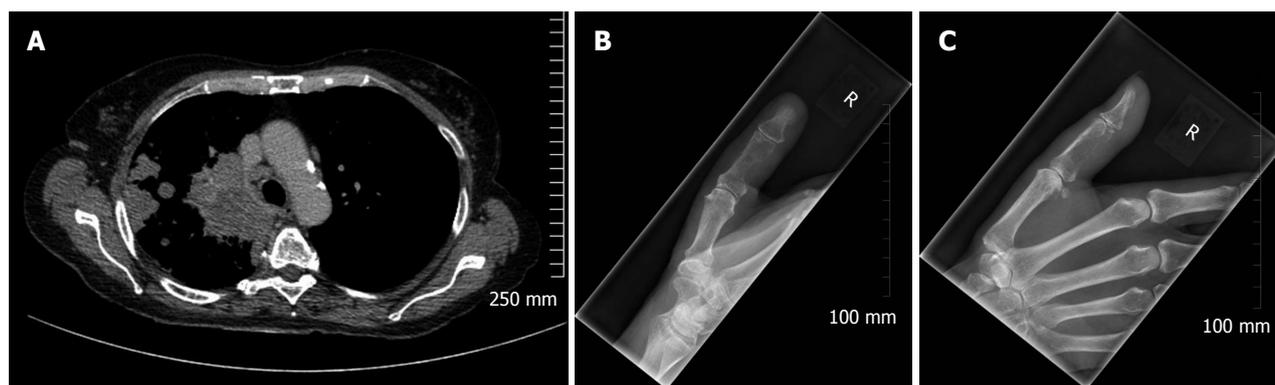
Bone metastasis in the appendicular skeleton is most commonly due to primary lung malignancy. A: Axial computed tomography image of the upper thorax (soft tissue window) demonstrating a large right upper lobe mass with ipsilateral pulmonary and lymph node metastasis; B and C: PA and lateral views of the right thumb demonstrating a lytic metastatic deposit in the middle phalanx.
